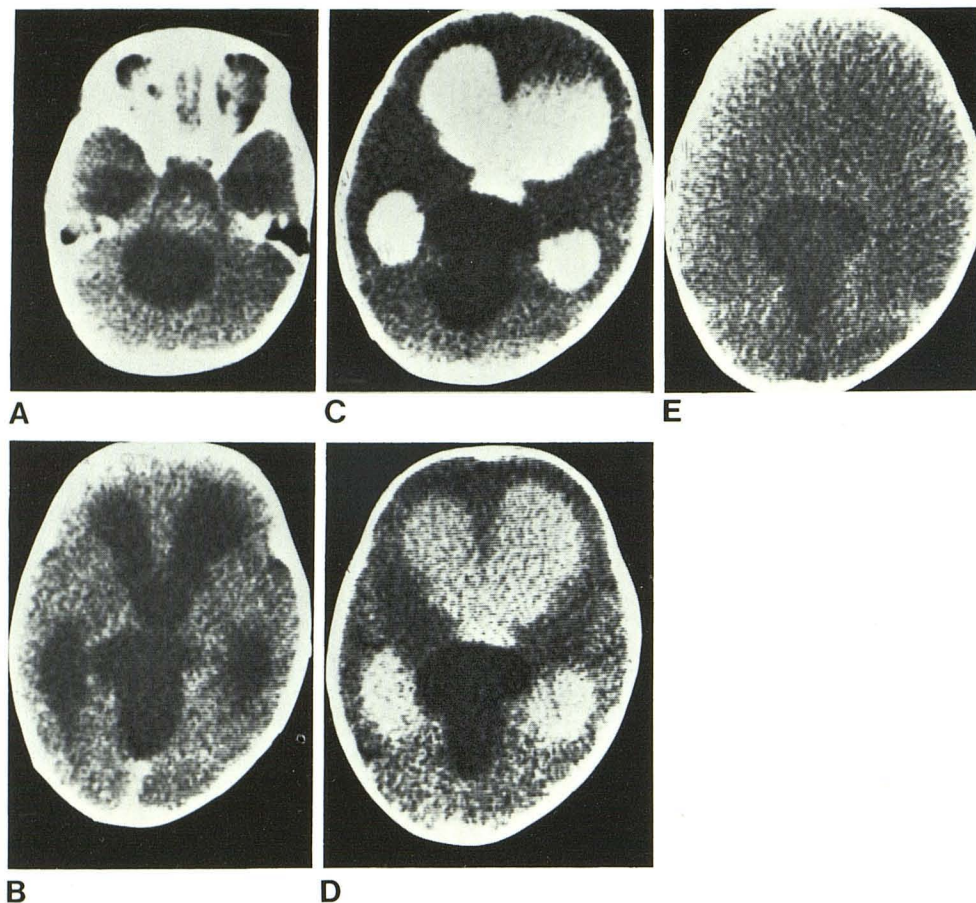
Case 5, 10-month-old child with quadrigeminal cistern cyst. A and B, Cyst extends from posterior fossa through incisura. Ventricular dilatation indicative of internal obstructive hydrocephalus. C–E, Metrizamide CT ventriculogram. No metrizamide within cyst at 2 hr (C), but at 24 (D) and 48 (E) hr, there is a slow diffusion of metrizamide into cyst.
